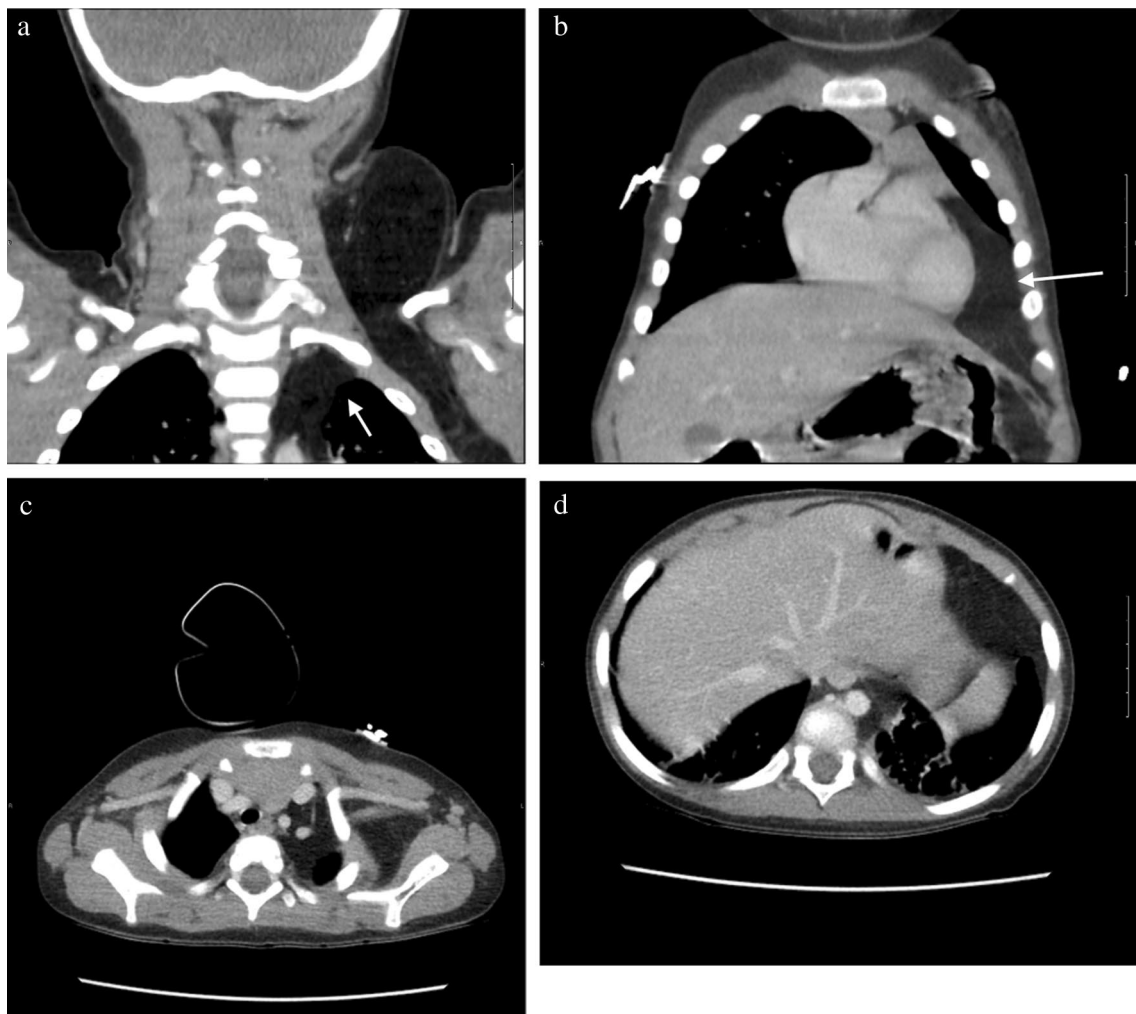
a Coronal CT Neck presents with large lobulated fat attenuating mass in the left neck extending into the left axilla, left superior mediastinum and left heart border (white arrow). b CT Coronal of the Chest/Abdomen presents with a fat attenuating mass extending from the left heart border to the abdominal cavity (white arrow). c CT Axial of the Neck presents with a fat attenuating mass characterized above extending from leftward neck mediastinum encasing the left carotid and subclavian arteries. d CT Axial of the Chest presents with a fat attenuating mass with encasement of the aorta by the mass at the diaphragmatic hiatus
